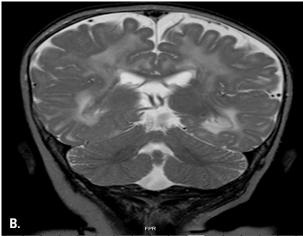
Brain magnetic resonance imaging in merosin-deficient muscular dystrophy. Axial (A) and coronal (B) T₂-weighted images showing high-signal changes in cerebral white matter. In a minority of cases of merosin-deficient CMD, these changes are associated with migrational anomalies.
